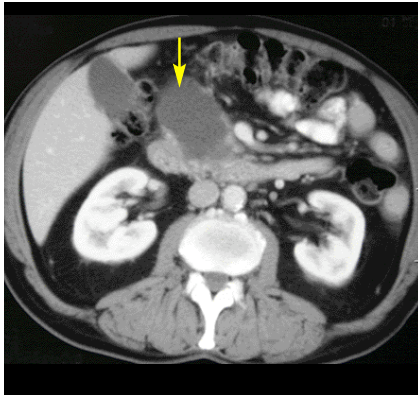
Axial CT scan of the abdomen showing a pancreatic pseudocyst (arrow). Aspiration of the fluid under endoscopic ultrasonography guidance showed a high amylase level and absence of tumour markers.
